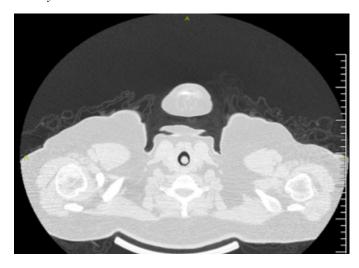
Appearance of a lesion occupying 80% of the tracheal lumen on high-resolution computed tomography.
